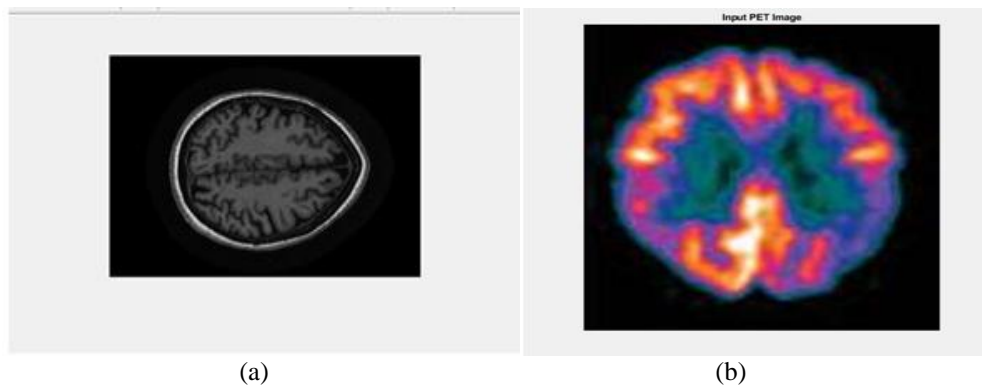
(a) Input MRI image (b) Input PET image
